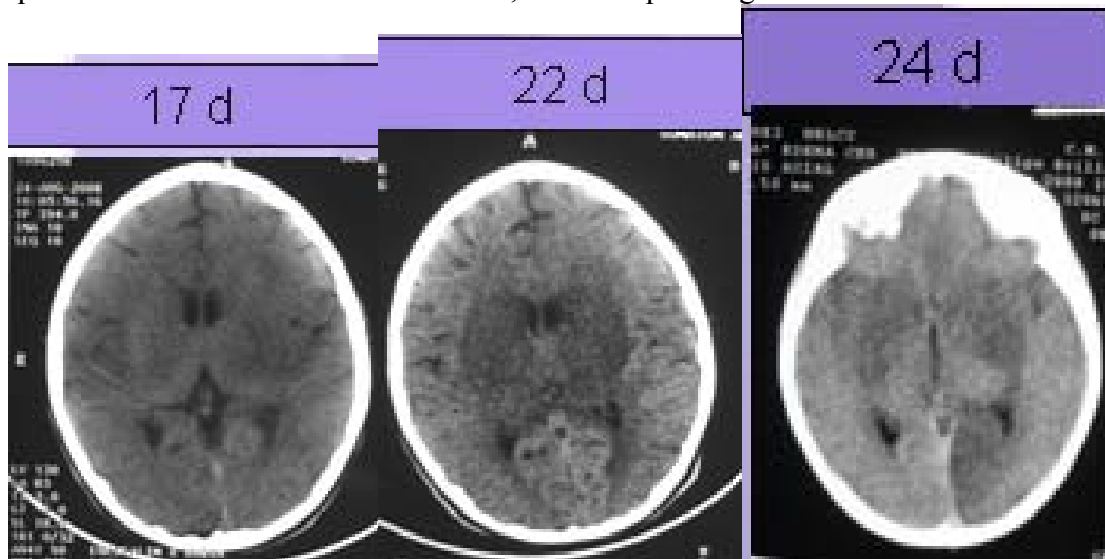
Progression of edema, initially in the basal ganglia with later cortical edema by CT. The edema was temporally associated with rapid increase in the rabies immune response. Despite severe edema of the basal ganglia (normally such edema would be catastrophic if cytopathic), the survivor had virtually normal basal ganglia by MRI after discharge from the ICU and, after demise from an unrelated event, had normal neuronal complement in the basal ganglia at autopsy.
